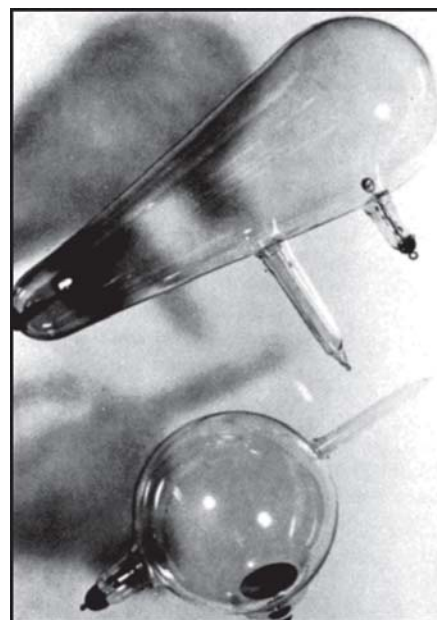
Hittorff- Crooke's tubes, of the kind used by Roentgen to discover X-rays
